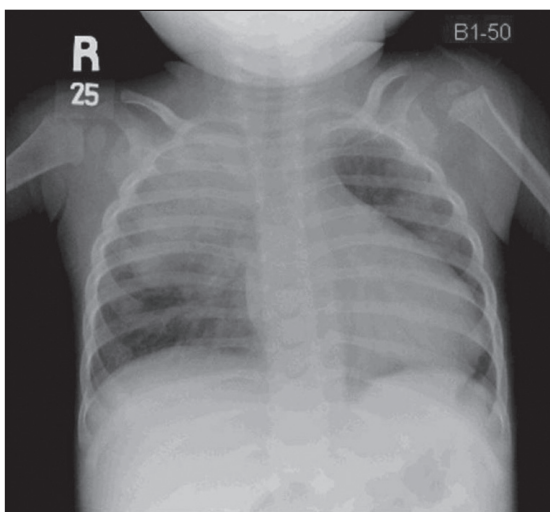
Chest x-ray upon admission to hospital.
